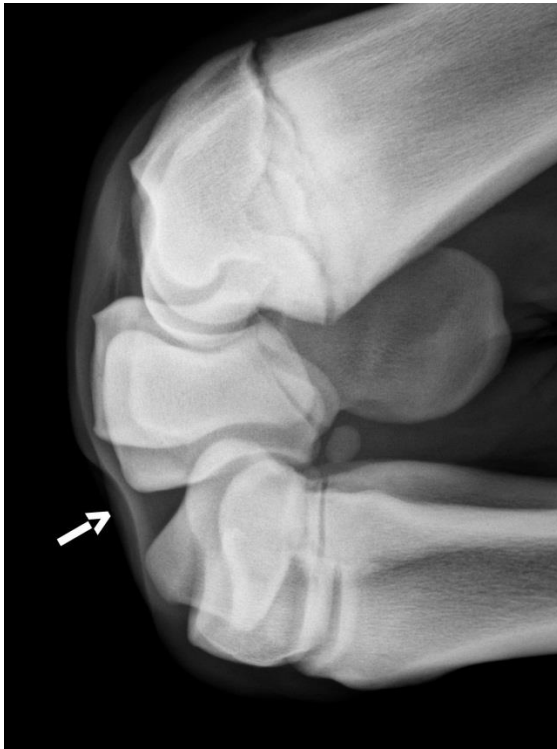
Flexed lateromedial radiographic view of carpus showing the dorsal surface of the radial carpal bone and 'cutting back' of the normally sharp 90° edge of the dorsodistal joint margin of this bone (arrow).
